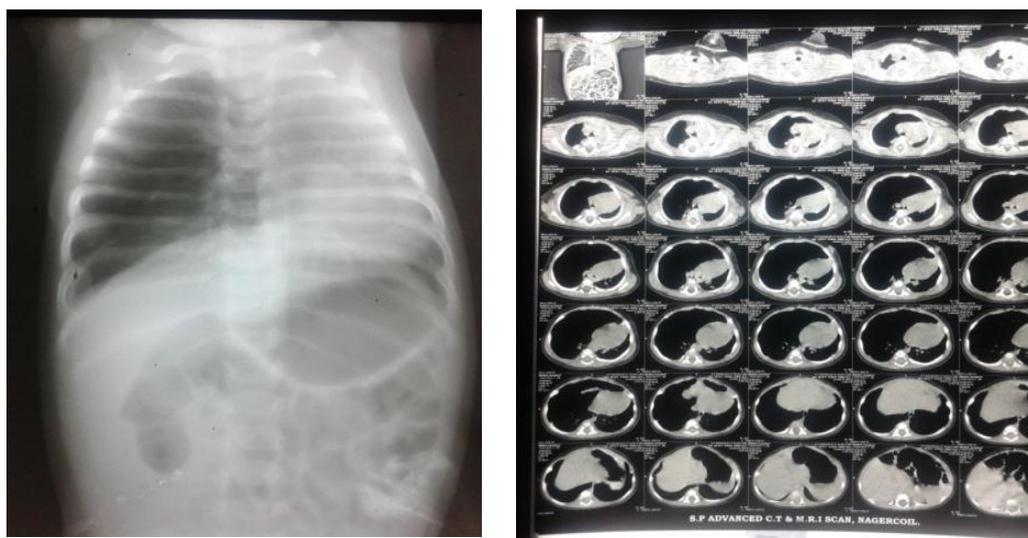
X-ray (Fig1) and CT.
